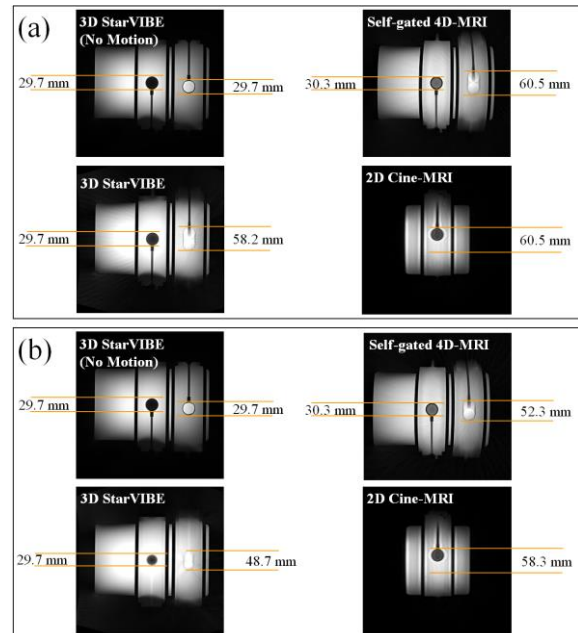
Tumour motion range measured on 3D StarVIBE with/without motion. Self-gated 4D-MRI and 2D Cine-MRI. Produced (a) a sine wave and (b) lung tumour motion during MRI scans.
